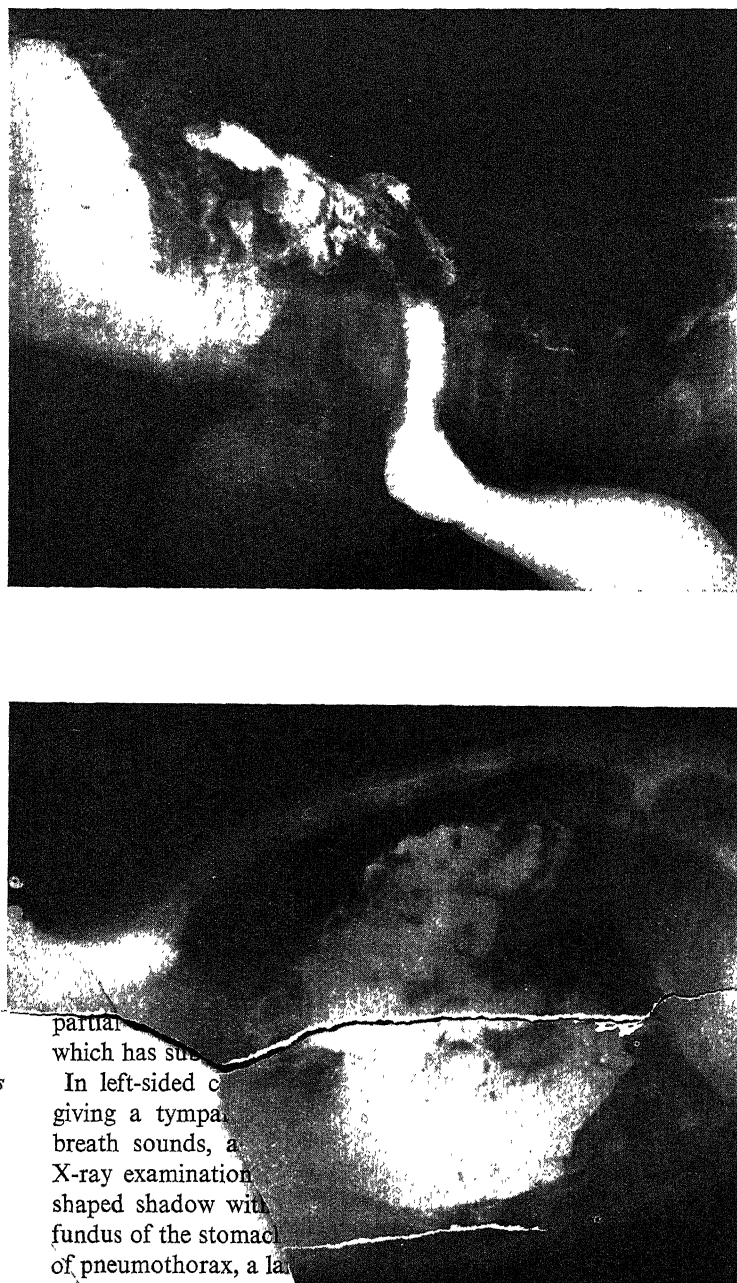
A. Lateral view of thorax of man aged 44. Absence of left diaphragm discovered on X-ray examination. The greater part of small intestine is seen lying in left pleural cavity. B. Same case, left oblique view. The stomach is rotated to left and the duodenum runs upwards into the left pleural cavity, proving the condition to have been congenital
